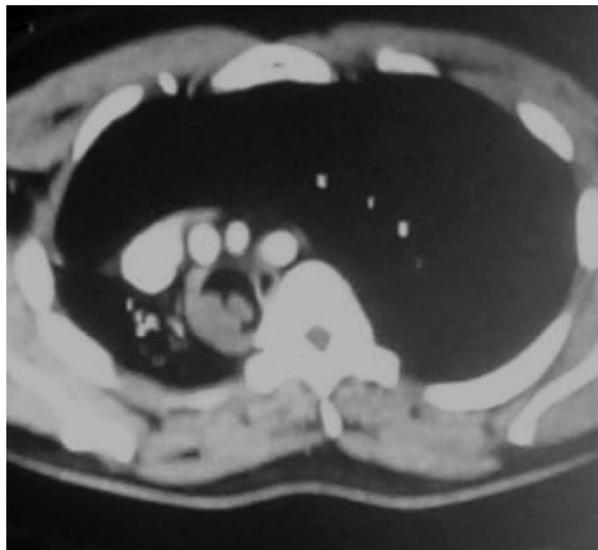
CT Thorax axial cut with intra tracheal polypoidal mass
